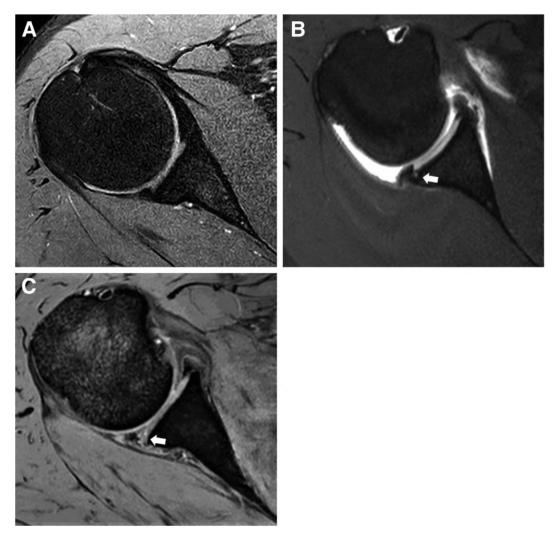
Three types of posterior labral tears of right shoulder in MRI/MRA. (A) Type 1, an occult tear with a normal posterior labral structure without evidence of labral detachments or cracks. (B) Type 2, an incomplete tear with a partial detachment (arrow) in superficial aspect of the posterior labrum without evidence of a complete tear or contrast leakage. (C) Type 3, a complete tear (arrow) in which the posterior labrum is detached from the glenoid. (MRA, magnetic resonance arthrography; MRI, magnetic resonance imaging.)
